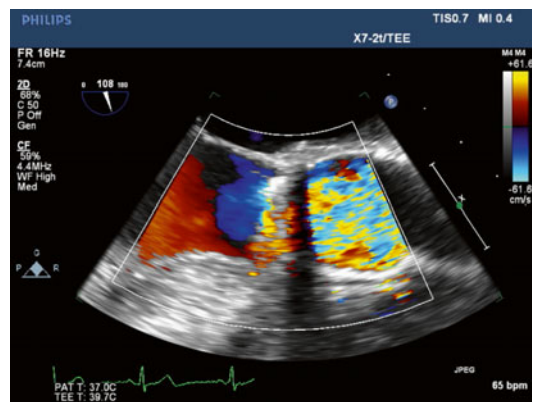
Color Doppler through the mechanical aortic valve on trans-esophageal imaging
